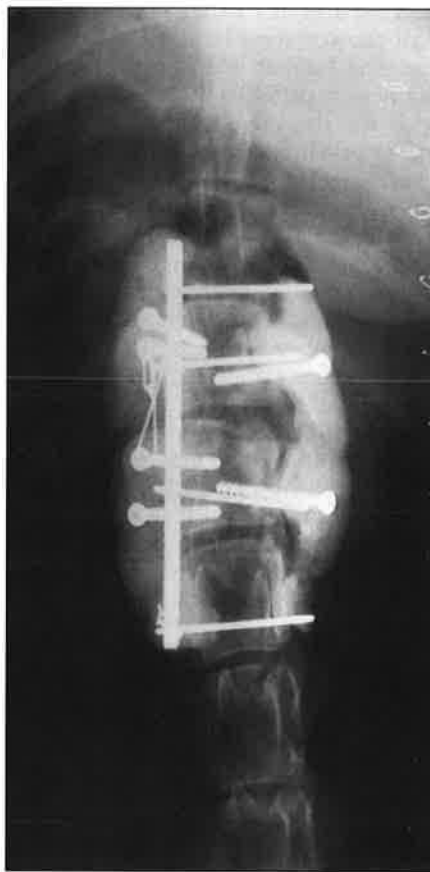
Dorsoventral radiographic view of T13-L3 after surgical straightening and fusion of the vertebrae.
